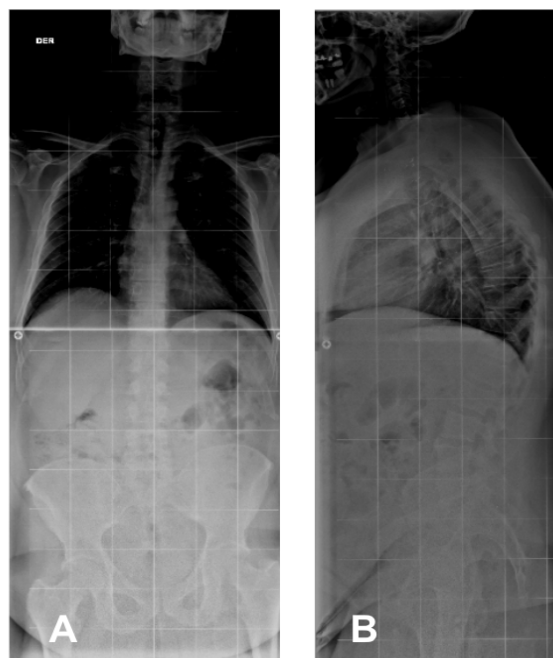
Full spine X-rays, anteroposterior (A), and lateral (B) views.
